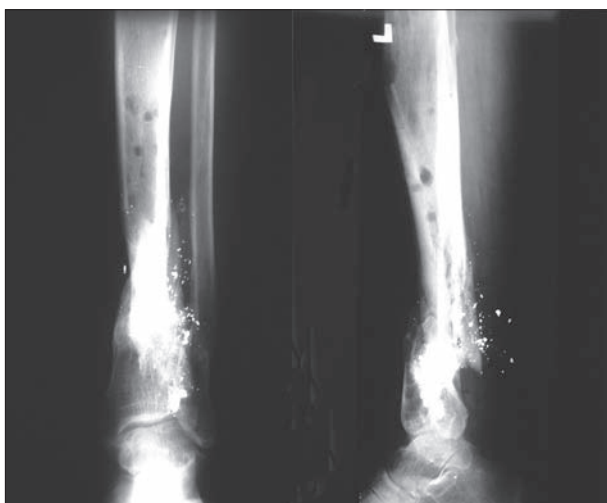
X-rays of the left lower leg 6 years after the injury
